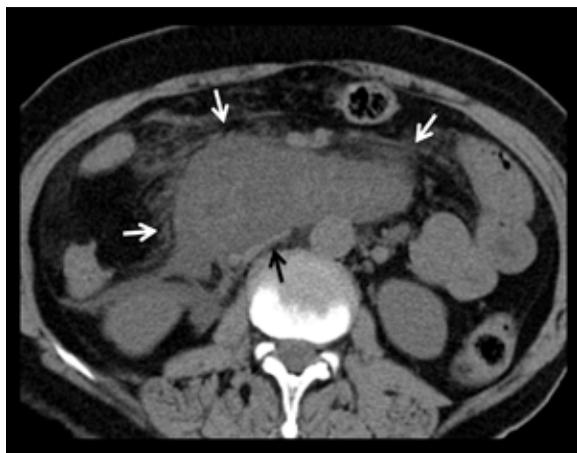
Acute duodenitis following diagnostic upper gastrointestinal endoscopy. Axial unenhanced CT scan at the level of the third part of duodenum demonstrates extensive duodenal inflammation (*white arrows*) and periduodenal fat stranding. Compression of the inferior vena cava is also noted (*black arrow*).
